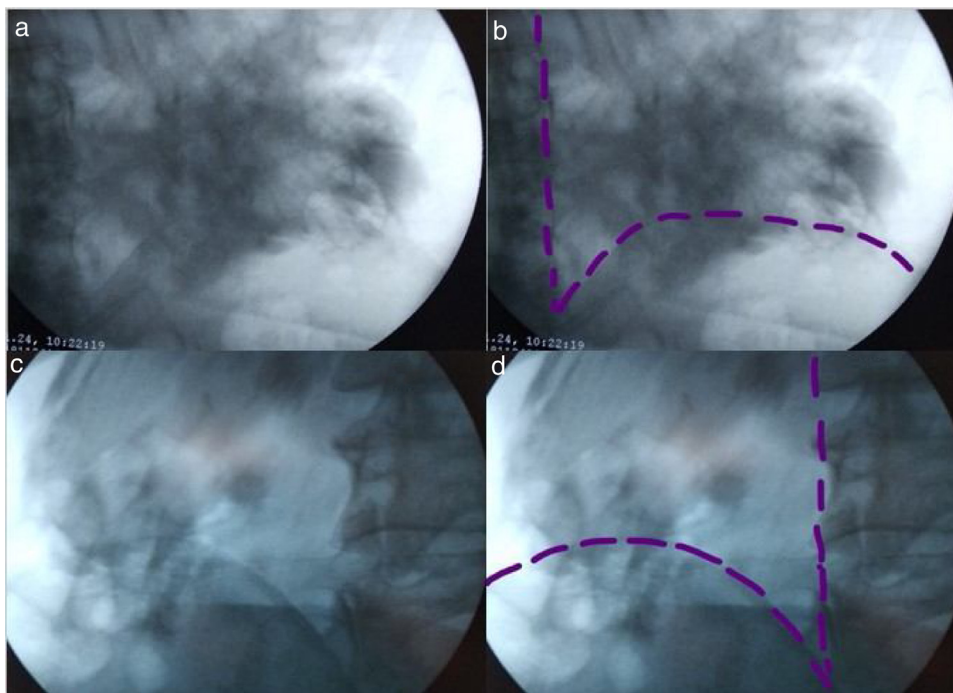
Frontal radiograph of the lumbo-sacral region to observe the pattern of contrast-LA mixture spread using C-Arm X-Ray Machine. (a and b) Left lumbo-sacral region in Case 3. (c and d) Right lumbo-sacral region in Case 4. The dark shadow represents the pattern of contrast-LA spread, purple dotted lines represent iliac crest and vertebral column borders.
